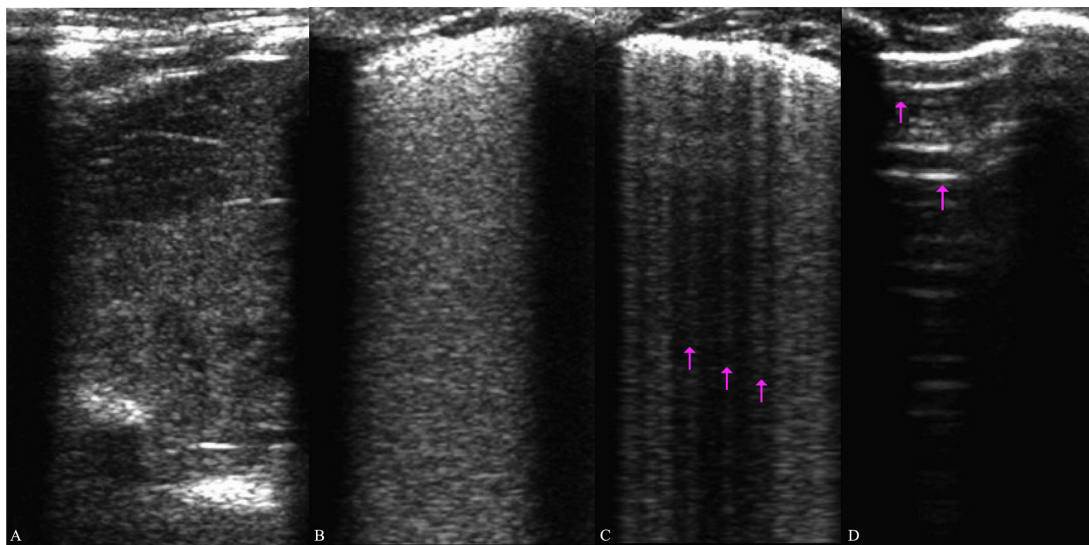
Lung ultrasound image of high-frequency oscillatory ventilation lambs: (A) before start ventilation, extended consolidations. (B) Alveolar pattern (defined as the presence of crowded and coalescent B lines with or without consolidations limited to subpleural space), image from a lamb with 1 min of ventilation. (C) Interstitial pattern (defined as the presence of ≥3 B lines (pink arrows), well-spaced), image from a lamb with 8 min of ventilation. (D) Normal aerated lung (defined by the presence of only A lines (pink arrows)), image from a lamb with 20 min of ventilation.
